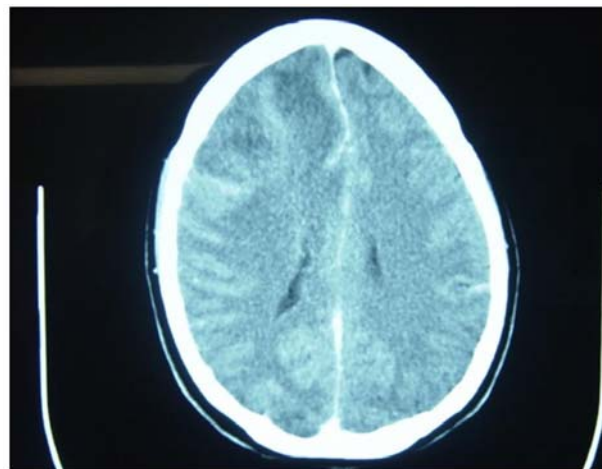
Axial CT brain showing evidence of hypodense area in right frontal area with minimal midline shift
